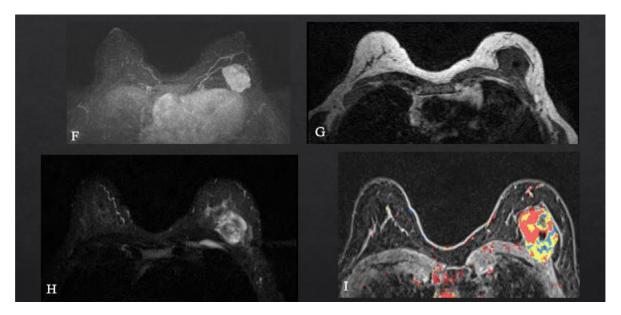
MRI images [(F) Maximum Intensity Projection Image, (G) T1 without contrast, (H) T1 with contrast enhancing, and (I) T1 with contrast and color mapping] show a circumscribed mass with a kinetics pattern of at worst rapid initial enhancement followed by washout at the left breast. There is a signal void from the biopsy clip in the center of this enhancing mass. This mass is close to the pectoralis muscle.
